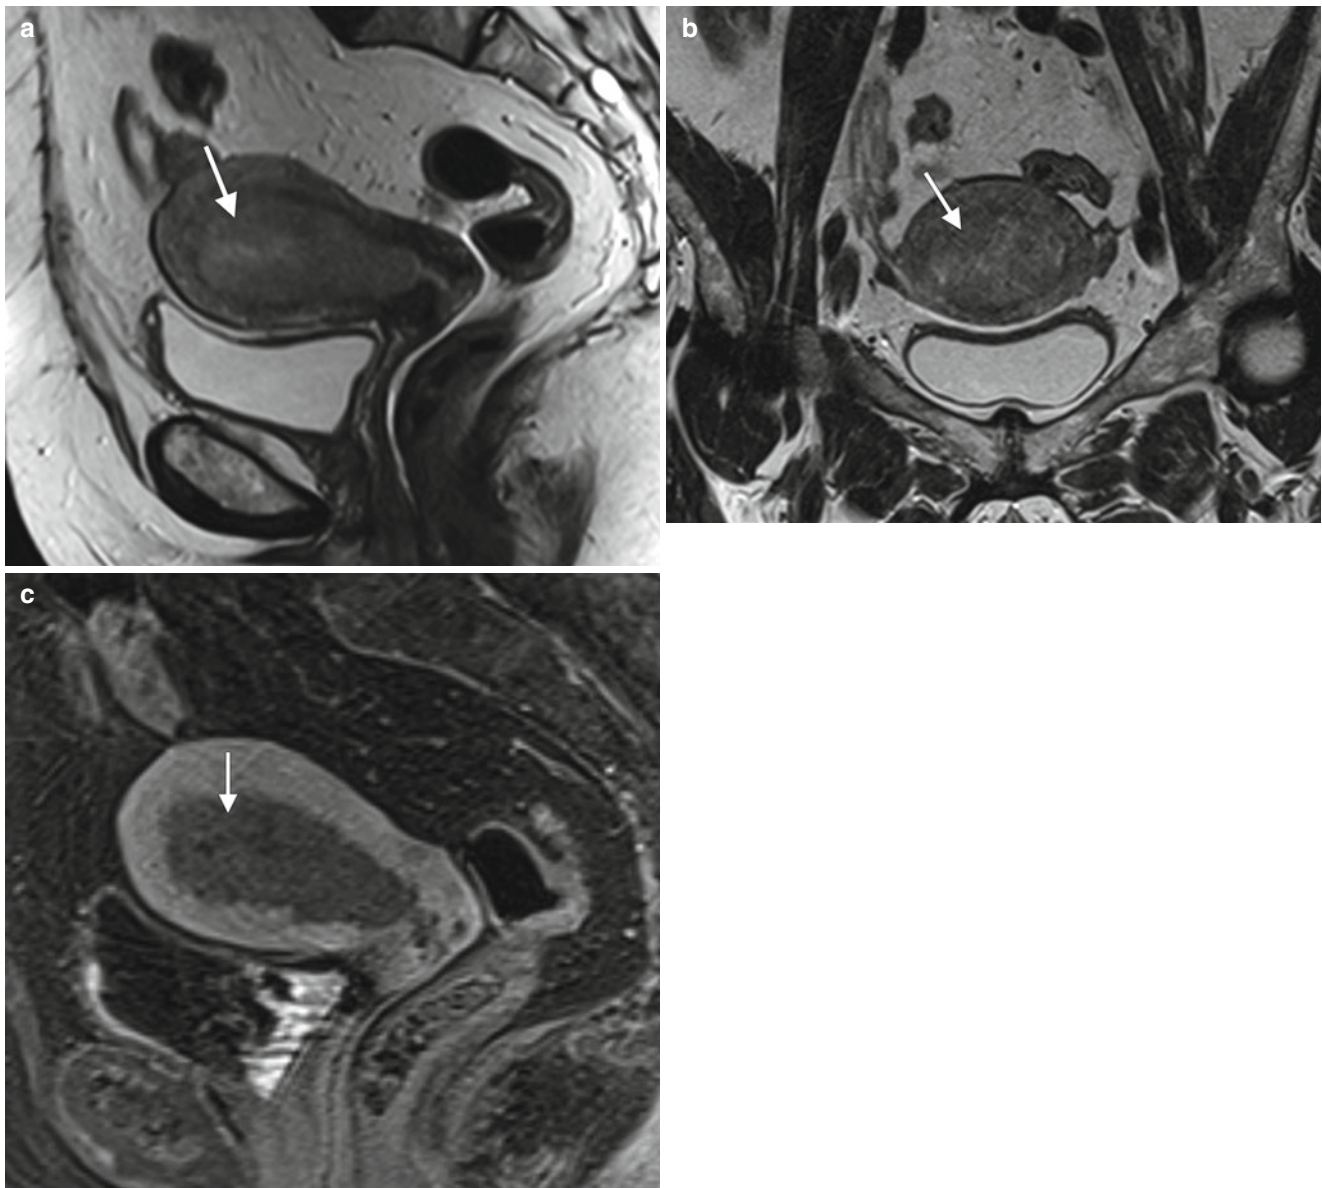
FIGO stage IB endometrial cancer in a 66-year-old woman with postmenopausal vaginal bleeding. Axial (a) and oblique coronal (b) T2-weighted MR images and a sagittal, fat-suppressed T1-weighted
